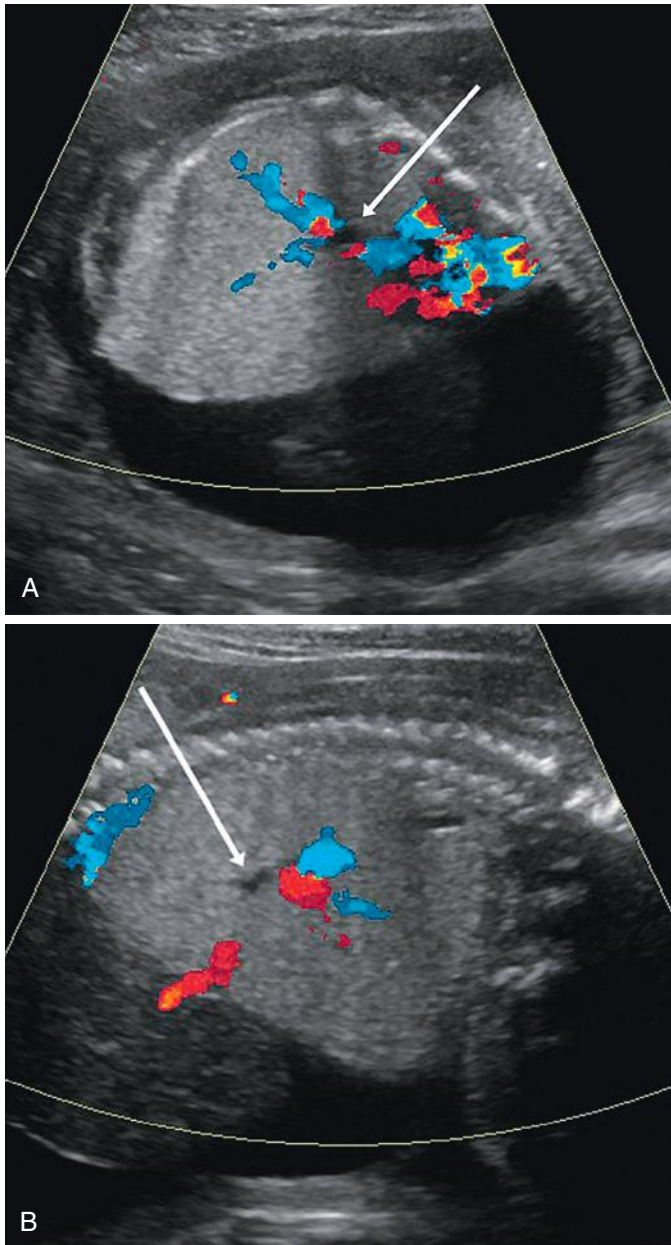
Color Doppler images through fetal chest. Axial (A) and sagittal (B) images demonstrate markedly enlarged echogenic lung, with eversion of the hemidiaphragm, consistent with bronchial atresia. Note fluid-filled airway (arrow).
